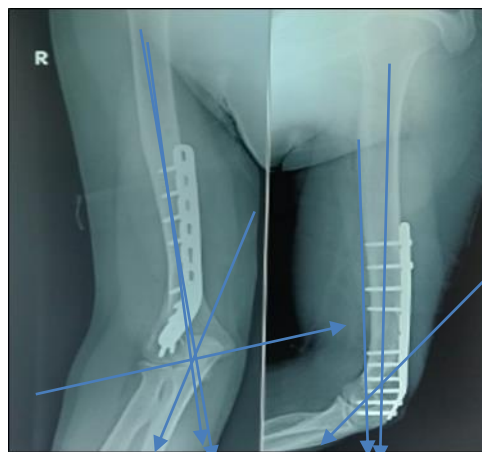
Showing radiological assessment on a Post Op x-ray.
